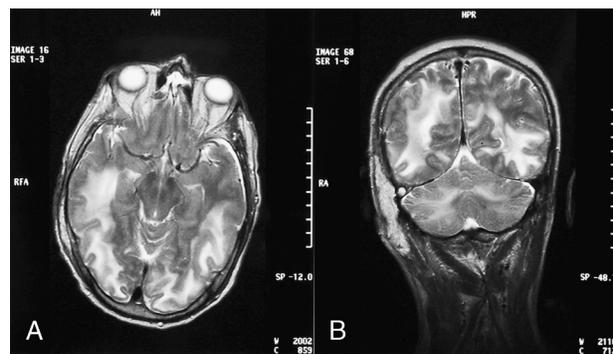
Cranial magnetic resonance at clinical manifestation time. A, Axial T2-weighted magnetic resonance image demonstrates hyperintensity in the white matter bilaterally in the parieto-occipital regions and both cerebellar hemispheres. B, Coronal T2-weighted magnetic resonance image shows bilateral areas of T2-weighted signal hyperintensity involving the parietal, occipital, and infratentorial lobes with involvement of the overlying cortex and mass effect.
